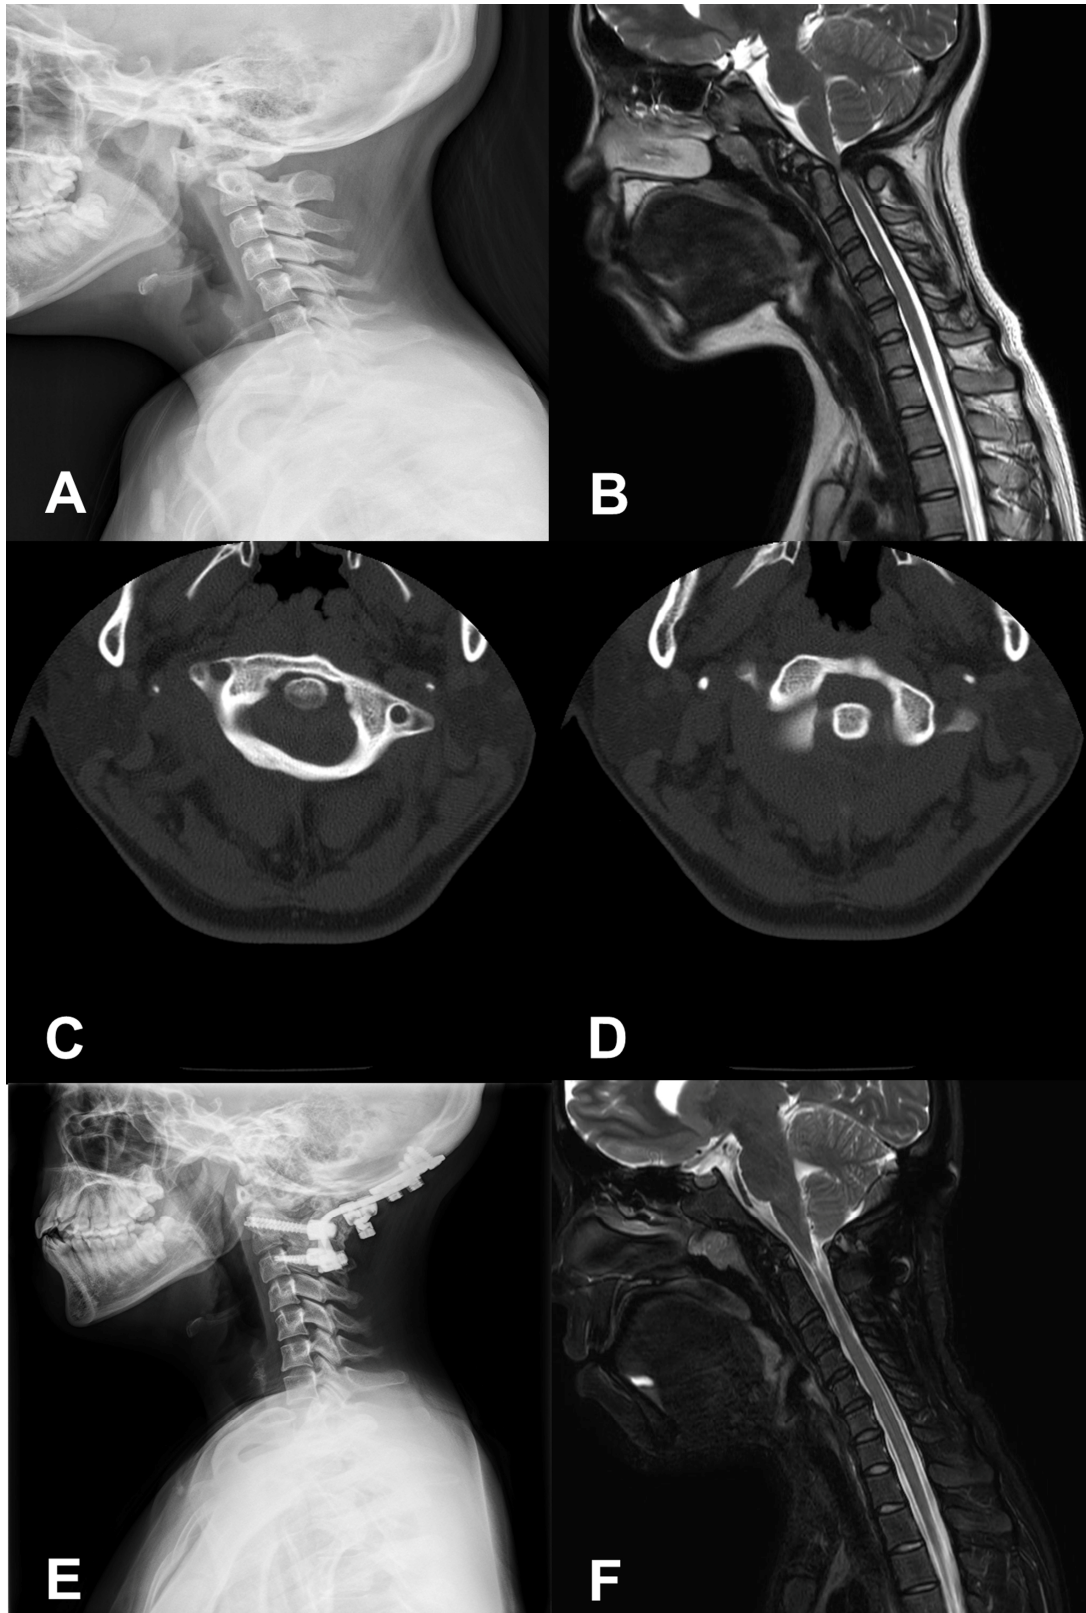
The radiologic findings of the initial and postoperative state. A: Lateral view of cervical spine x-ray. The fracture of odontoid process was demonstrated. B: The initial MRI of cervical spine. MRI showed narrowing cervical canal, fracture of odontoid process, and cervical myelopathy at C1/C2. C, D: Axial view of initial CT of cervical spine. CT demonstrated old odontoid process fracture, anterior displacement of fractured odontoid process and C1. E: Lateral view of cervical spine x-ray at postoperative state. Laminectomy and posterior metallic fixation at C1-3 were shown. F: The follow-up MRI of cervical spine at postoperative state. MRI showed marked thinning with increased signal intensity in spinal cord at C2 level, myelomalacia with atrophic change of spinal cord.
